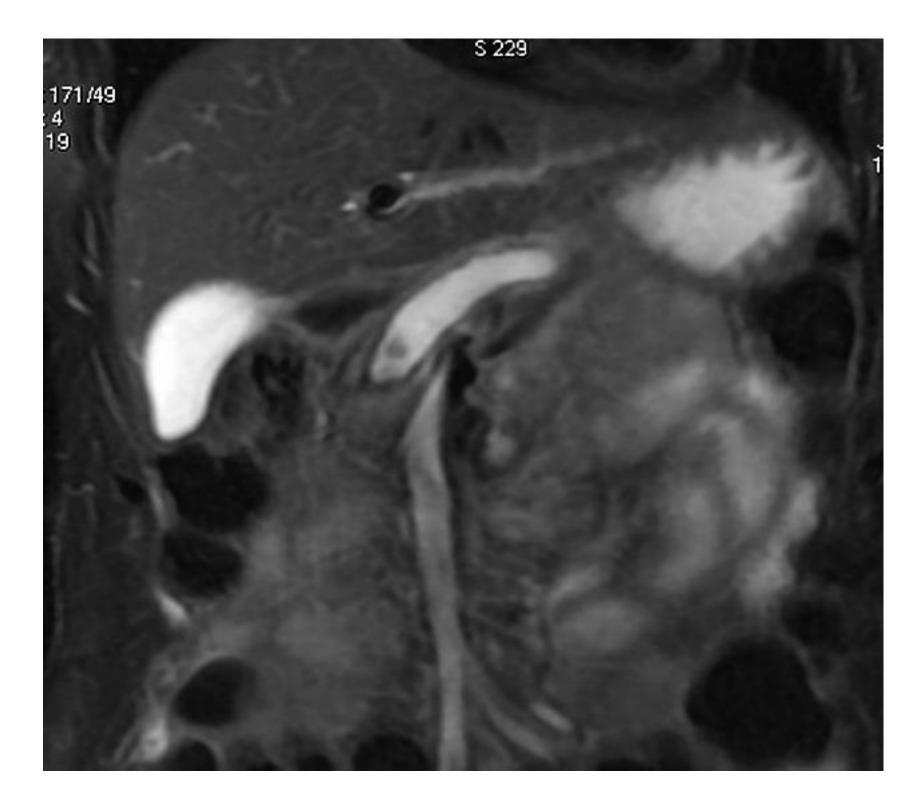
MRI, T2- irregular dilatation of pancreatic duct, and multiple intraductal calculi
